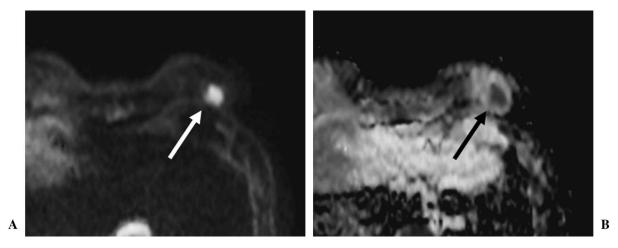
A 56-year-old woman with left breast cancer diagnosed as axillary lymph node (N)-positive, nuclear grade (NG) 3, estrogen receptor (ER)-negative, progesterone receptor (PgR)-negative, and human epidermal growth factor receptor 2 (HER2) score 3 + . (A) A nodule with high signal intensity was detected in the left breast on diffusion-weighted imaging (DWI). (B) The apparent diffusion coefficient (ADC) value was 1.10×10^{-3} mm²/s on the ADC map.
